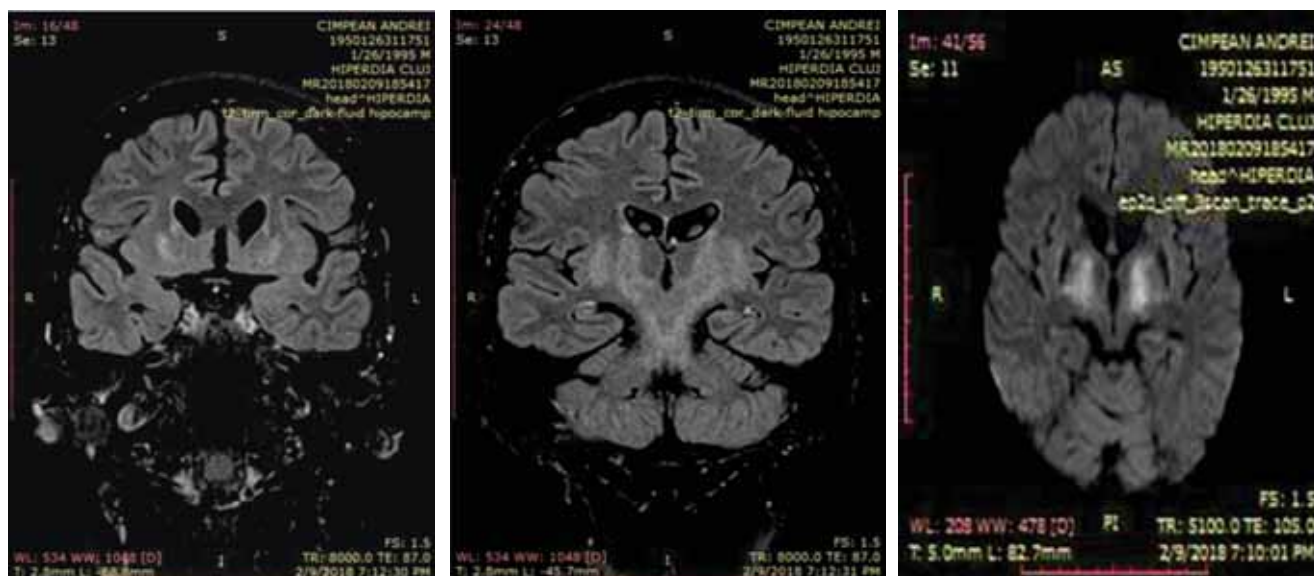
Brain MRI showing hyperintense T2 lesions located in the basal ganglia and thalamus
